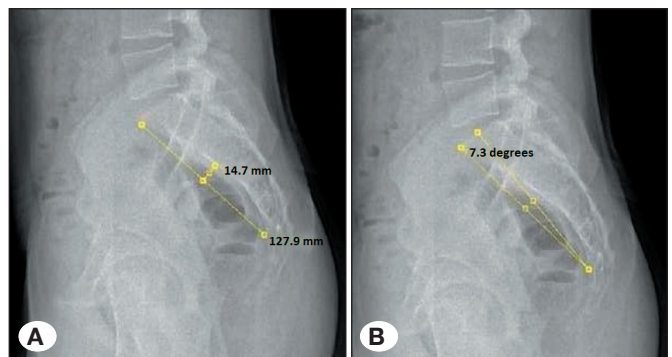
Lateral lumbosacral radiograph of a 20-year-old man with sacralization. The measurement of the ATA1 and ATA2 are shown in (A) and (B), respectively.
